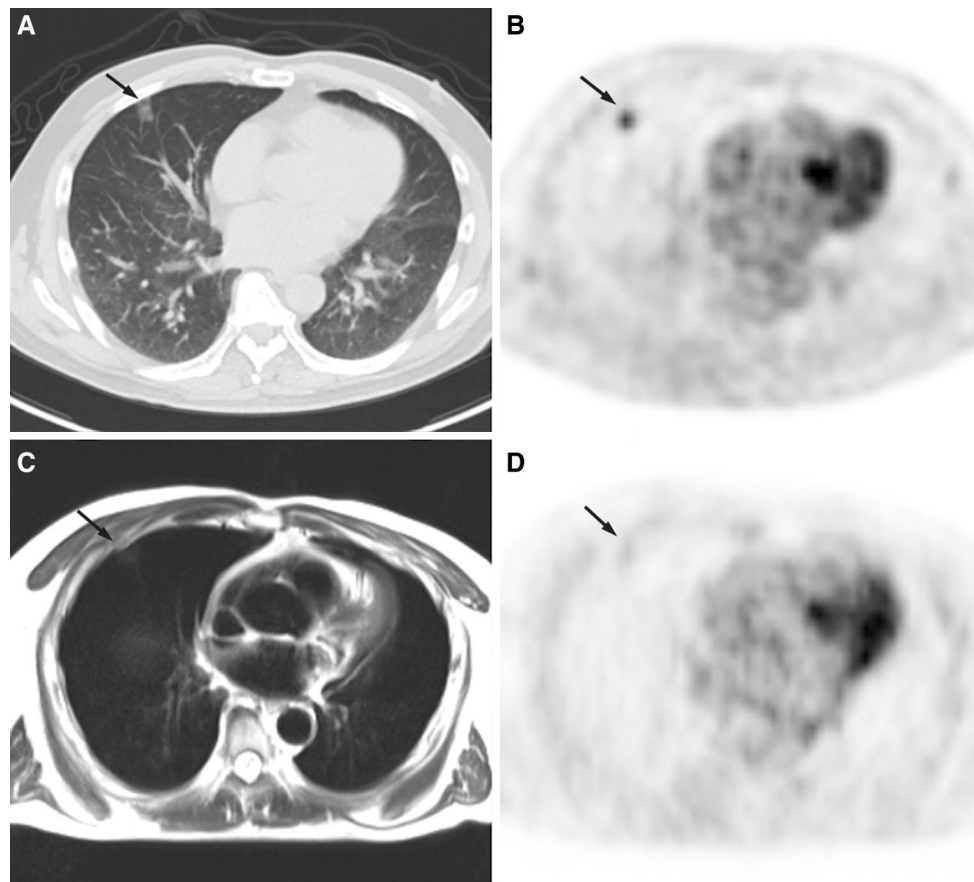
A 66-year-old man with lung adenocarcinoma. Axial CT image (a) and PET of PET/CT (b) show FDG-avid ground glass opacity in the right middle lobe (arrow). Although PET derived from
